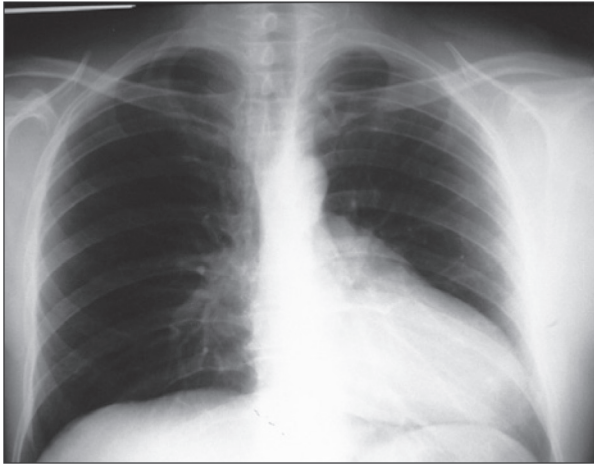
Chest X-ray: counterclockwise heart axis deviation.
